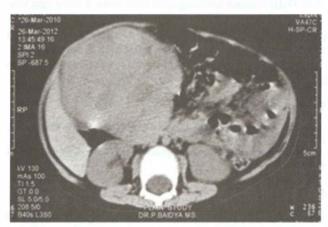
Computed tomography of abdomen shows suprarenal mass suggestive of neuroblastoma
